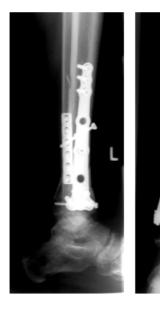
X-Rays after ORIF
